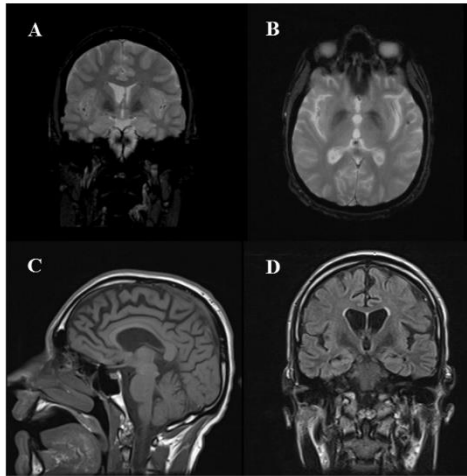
A) coronal brain MRI T2* sequences showing bilateral putaminal and globus pallidus hypointensity at age 26, possibly consistent with iron deposition, without “eye-of-the tiger” sign; B) axial brain MRI T2* sequences showing hypointensity of putamina, GPi, and substantia nigra at age 31; C-D) fronto-temporal cortical atrophy at age 31.
